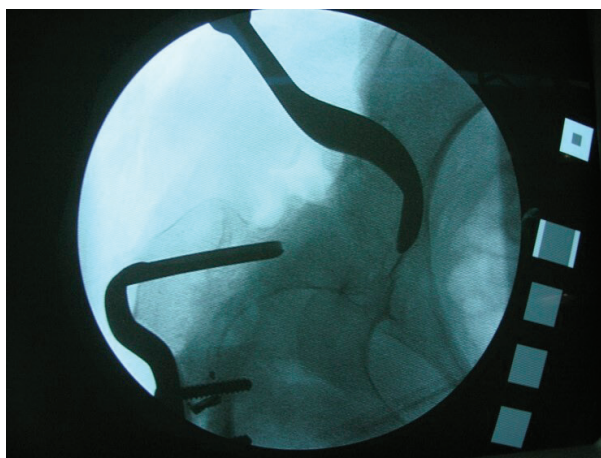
Intraoperative radiograph showing the semicircular chisel used for the semispheric periacetabular osteotomy.
